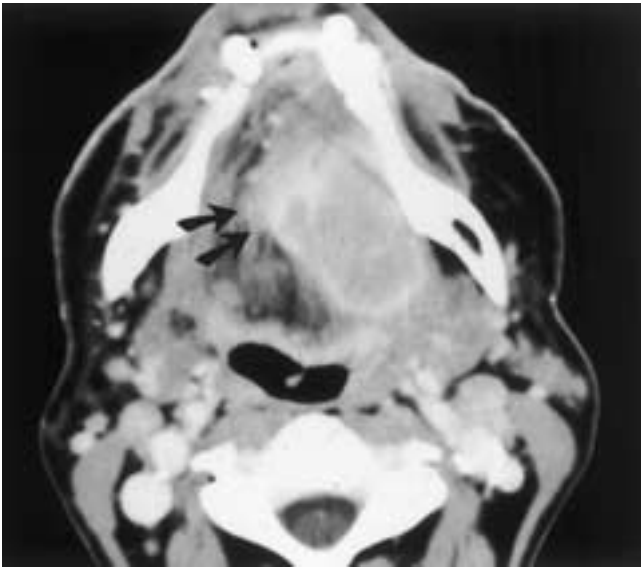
Oral tongue squamous cell carcinoma. Contrast-enhanced axial CT scan demonstrates a tumor of the left lateral oral tongue with medial extension across the midline to involve the right oral tongue (arrows). Although the tumor is fairly well defined posteriorly, it is poorly defined in its anterior extent and its margins are indistinct.
